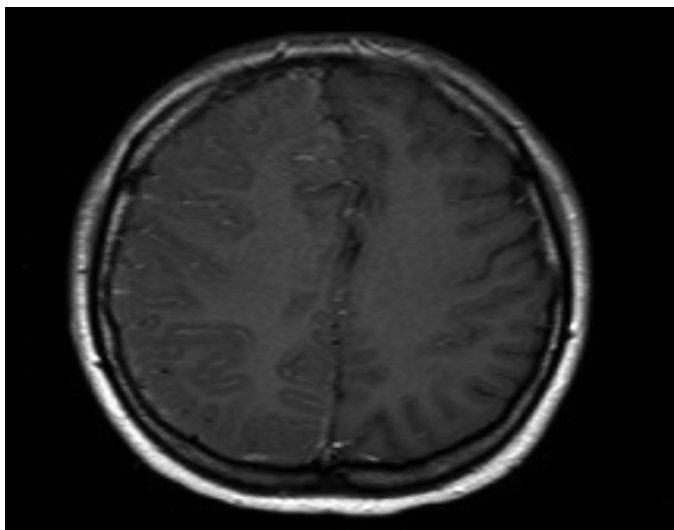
Contrast-enhanced cranial MRI (TR650, TE15): In the T1W-SE-weighted post-contrast images, the increase in calibration in the same-sided vascular structures compatible with the increase in perfusion draws attention
